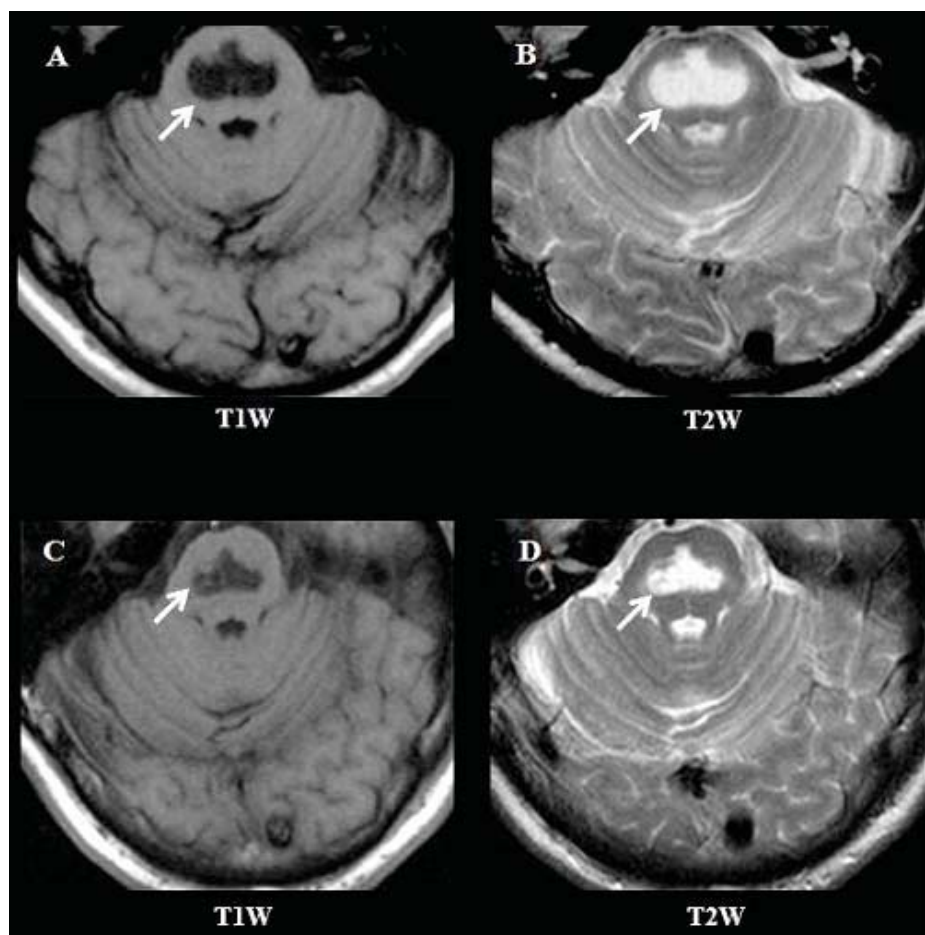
Axial brain magnetic resonance imaging scans show a well-defined trident-shaped T1-weighted (T1W) hypointense (A) and T2W hyperintense lesion (B) (arrows) suggestive of central pontine myelinolysis at baseline and 11 months after baseline (C, D).
